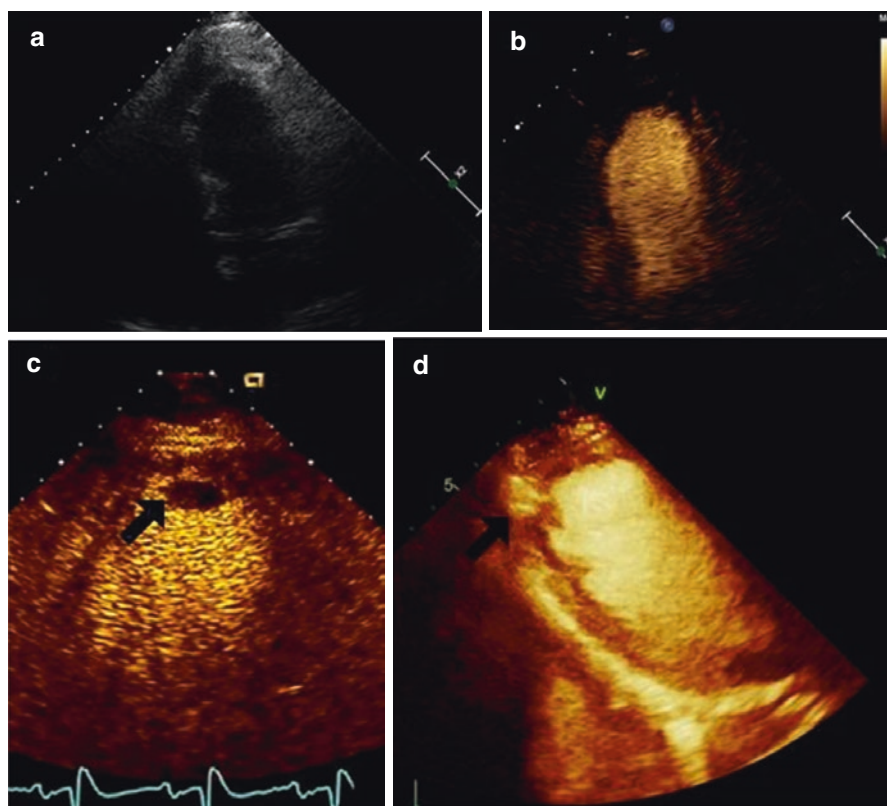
Advantages of contrast echocardiography. Suboptimal echocardiographic image quality is not uncommon in acute care settings making assessment of left ventricular size and function difficult (panel a). Use of echocardiographic echocardiography greatly increases the percentage of interpretable studies (panel b). Contrast echocardiography also facilitates the recognition of high-risk findings such as left ventricular apical thrombus (panel c, arrow) and left ventricular pseudoaneurysm (panel d, arrow)
